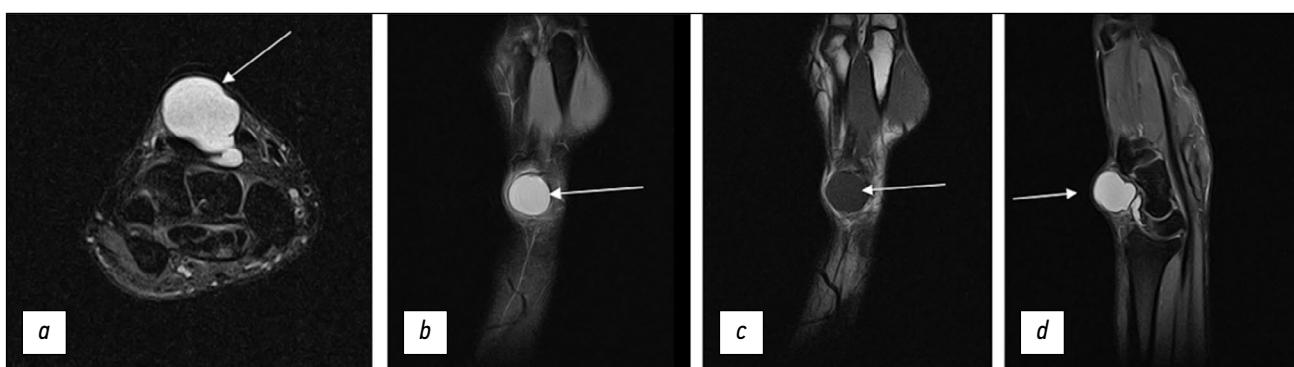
Large encapsulated ganglion cyst of the dorsal hand with neck-like connection to the wrist cavity; (a) PD-weighted images with fat suppression in the axial plane; (b) PD-weighted images with fat suppression in the coronal plane; (c) T1-weighted images in the coronal plane; (d) PD-weighted images with fat suppression in the sagittal plane.
